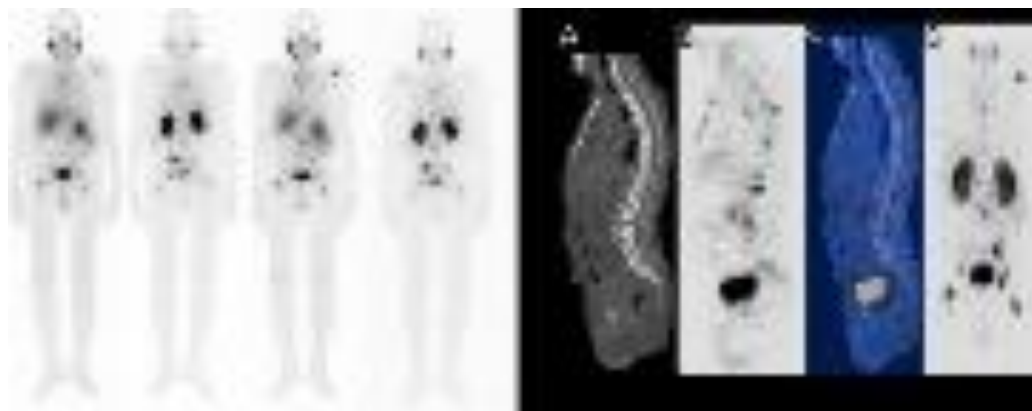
Whole body planar imaging of PSMA uptake showing abnormal foci of tracer uptake in the chest, liver and bones in patient having Ca Prostate with bony metastasis, on Zometa since December, 2020. A, B, C & D are the SPECT/CT images of PSMA uptake in multiple vertebra metastasis.
